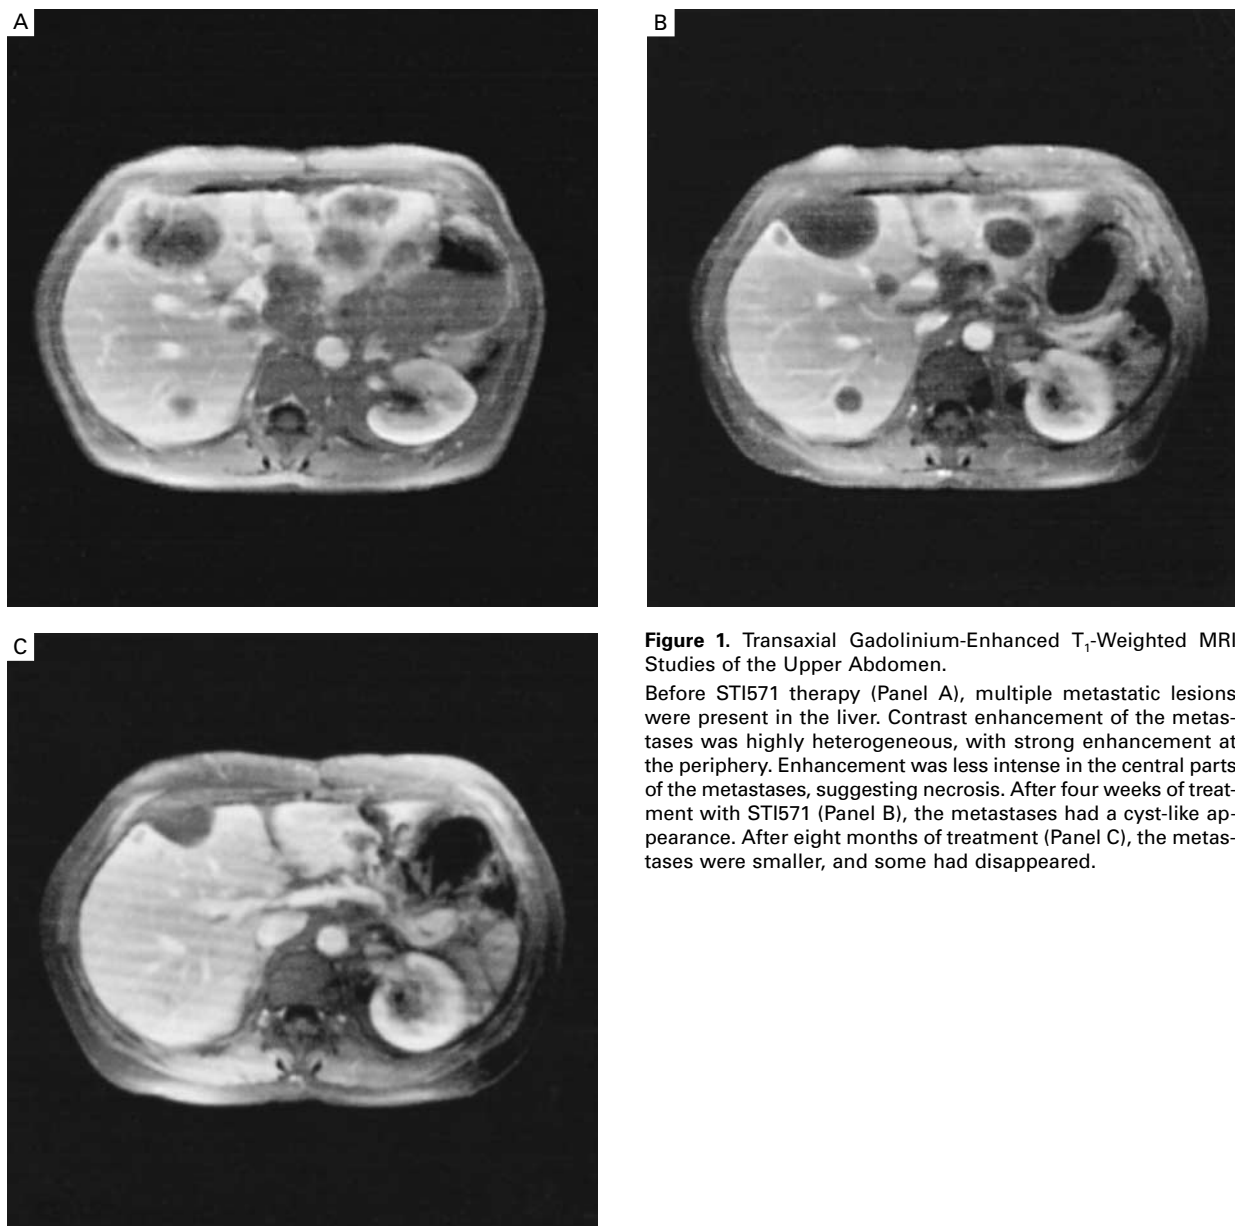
Transaxial Gadolinium-Enhanced T₁-Weighted MRI Studies of the Upper Abdomen.
